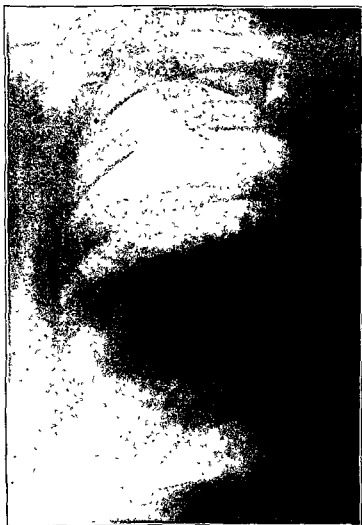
The right middle lobe shows a massive exudative involvement, not sufficiently dense or well marked off to indicate complete serous exudate in peripheral portions of the lobe. No internal markings disclose a pathologic pattern within the area. In this type and stage of involvement the x-ray findings are quite such as one expects in simple pneumonia.
